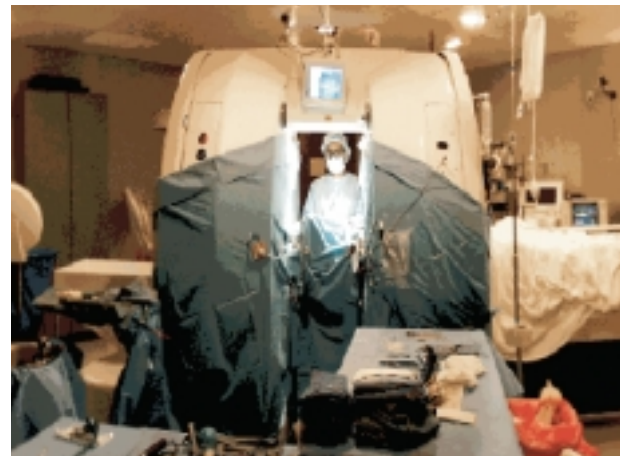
Using image-guided surgery, the surgeon is operating on the patient, who lies within the coils of the MRI. The screen, showing the patient's brain, is visible above the surgeon. This figure provided courtesy of Dr. Ferenc Jolesz, Brigham & Women's Hospital, MA.
